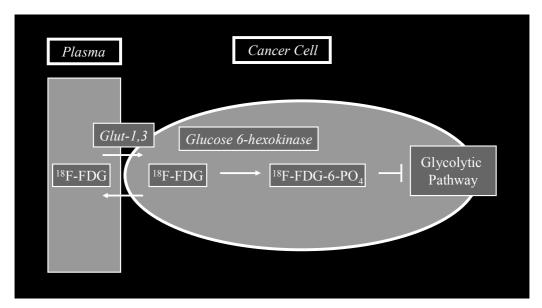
¹⁸F-FDG uptake by glucose transporters Glut 1 and 3, with subsequent phosphorylation and trapping of the phosphorylated ¹⁸F-FDG (¹⁸F-FDG-6-PO₄) in a cancer cell
